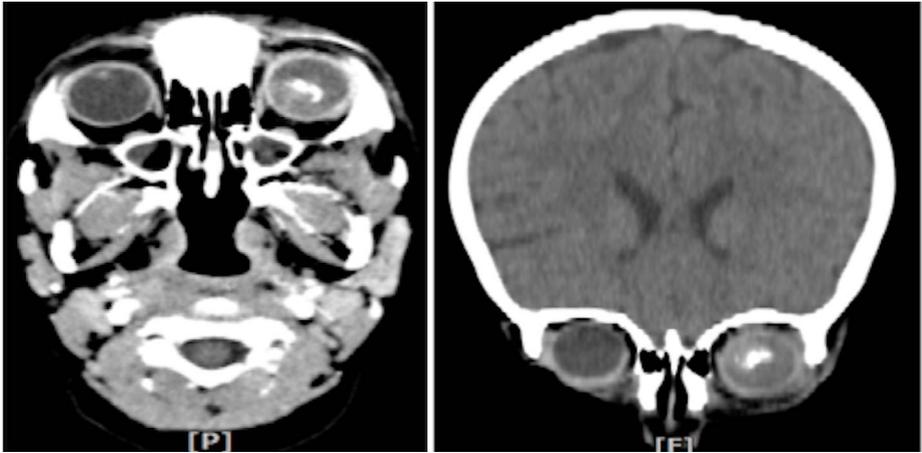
Computed tomography of the orbit showing intraocular hyperdensities in the left eye.
